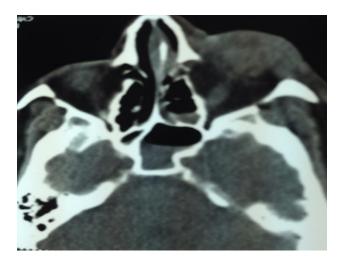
CT scan axial view showing proptosis.
